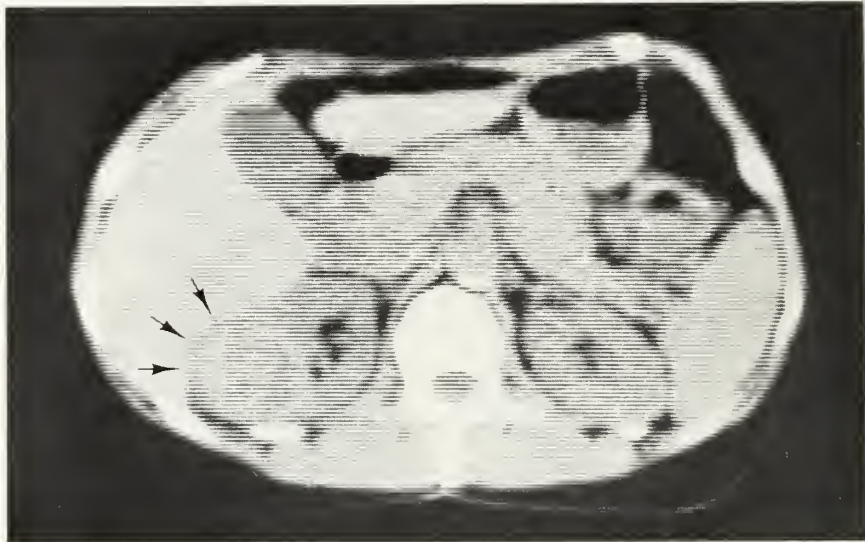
CT scan shows a solid tumor surrounded by a rim of hemorrhage (arrows).
